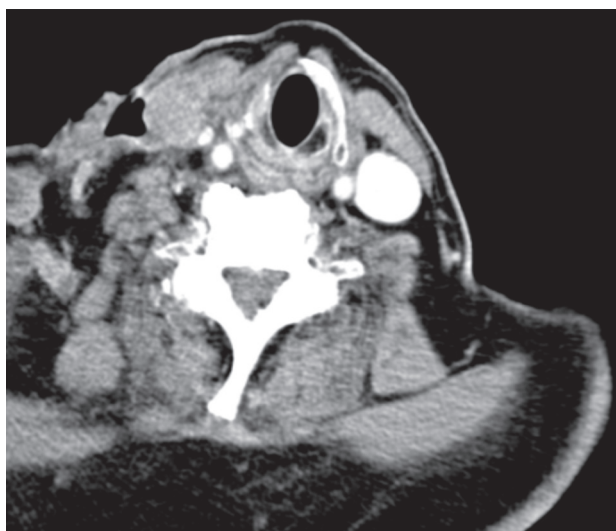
Neck CT revealing swollen lymph nodes with central melting and the abscess, surrounding the patient's right jugular vein, which appeared fine-spun (thin with decreased inner diameter) with a lack of repletion after contrast agent infusion, an image that set the suspicion of tuberculous lymphadenitis and of right jugular vein thrombosis.
